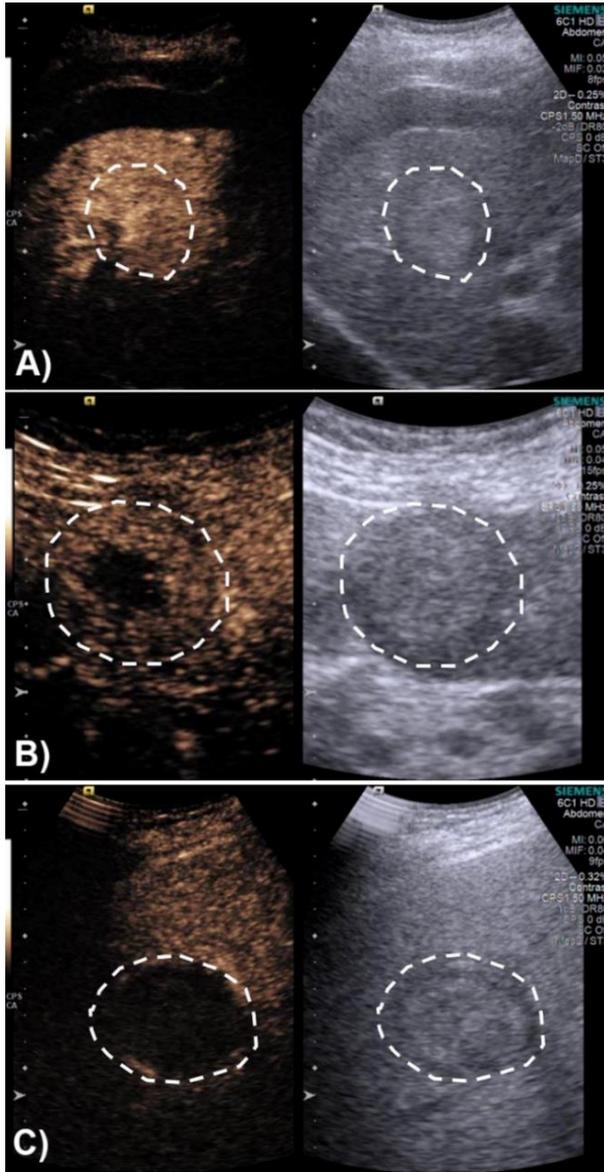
Representative CEUS images of HCC tumors 7 days post-radioembolization, tumors are delineated by white circles. Left image is CEUS, right is grayscale ultrasound. A) Tumor classified as stable disease (SD) with the entire tumor region showing echogenicity. B) Tumor classified as partial response (PR), with a hypoechoic region within the tumor suggesting necrotic tissue. C) Tumor classified as complete response (CR), with most of the tumor area appearing hypoechoic suggesting mostly necrotic tissue.
